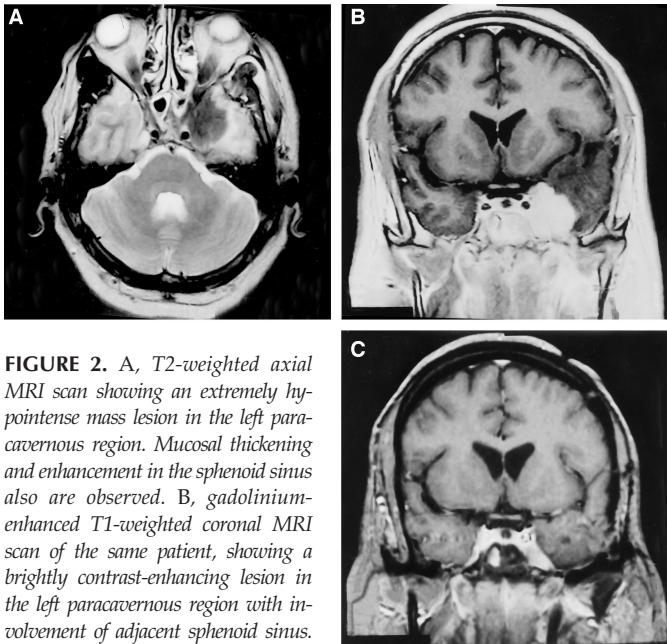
A, T2-weighted axial MRI scan showing an extremely hypointense mass lesion in the left paracavernous region. Mucosal thickening and enhancement in the sphenoid sinus also are observed. B, gadolinium-enhanced T1-weighted coronal MRI scan of the same patient, showing a brightly contrast-enhancing lesion in the left paracavernous region with involvement of adjacent sphenoid sinus. C, gadolinium-enhanced T1-weighted coronal MRI scan of the same patient 6 months after craniotomy, showing significant reduction in the size of lesion. This patient received a 2-week regimen of itraconazole preoperatively, then combined amphotericin B (cumulative dose of 3 g in 4 wk) and itraconazole. Itraconazole was continued for 12 months, and the patient has survived with moderate disability (GOS score, 4).
